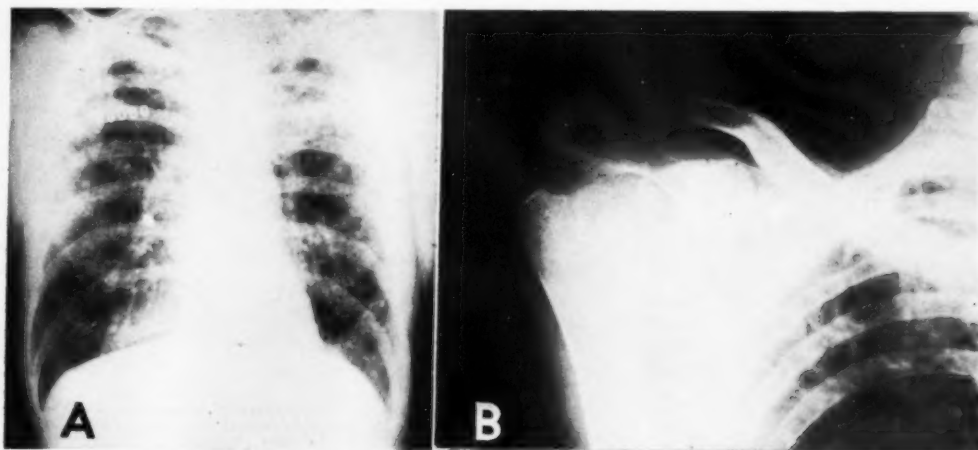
Case 5: Roentgenogram of chest (A) showing mycotic or tuberculous or mycotic and tuberculous lesions and (B) of shoulder showing mycotic infection.
